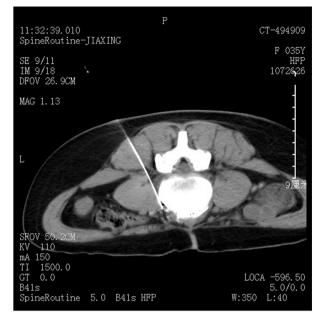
Computed tomography scan indicating that the injection drug fluid is distributed along the anteromedial margin of the psoas major muscle and the anterior vertebral body.
